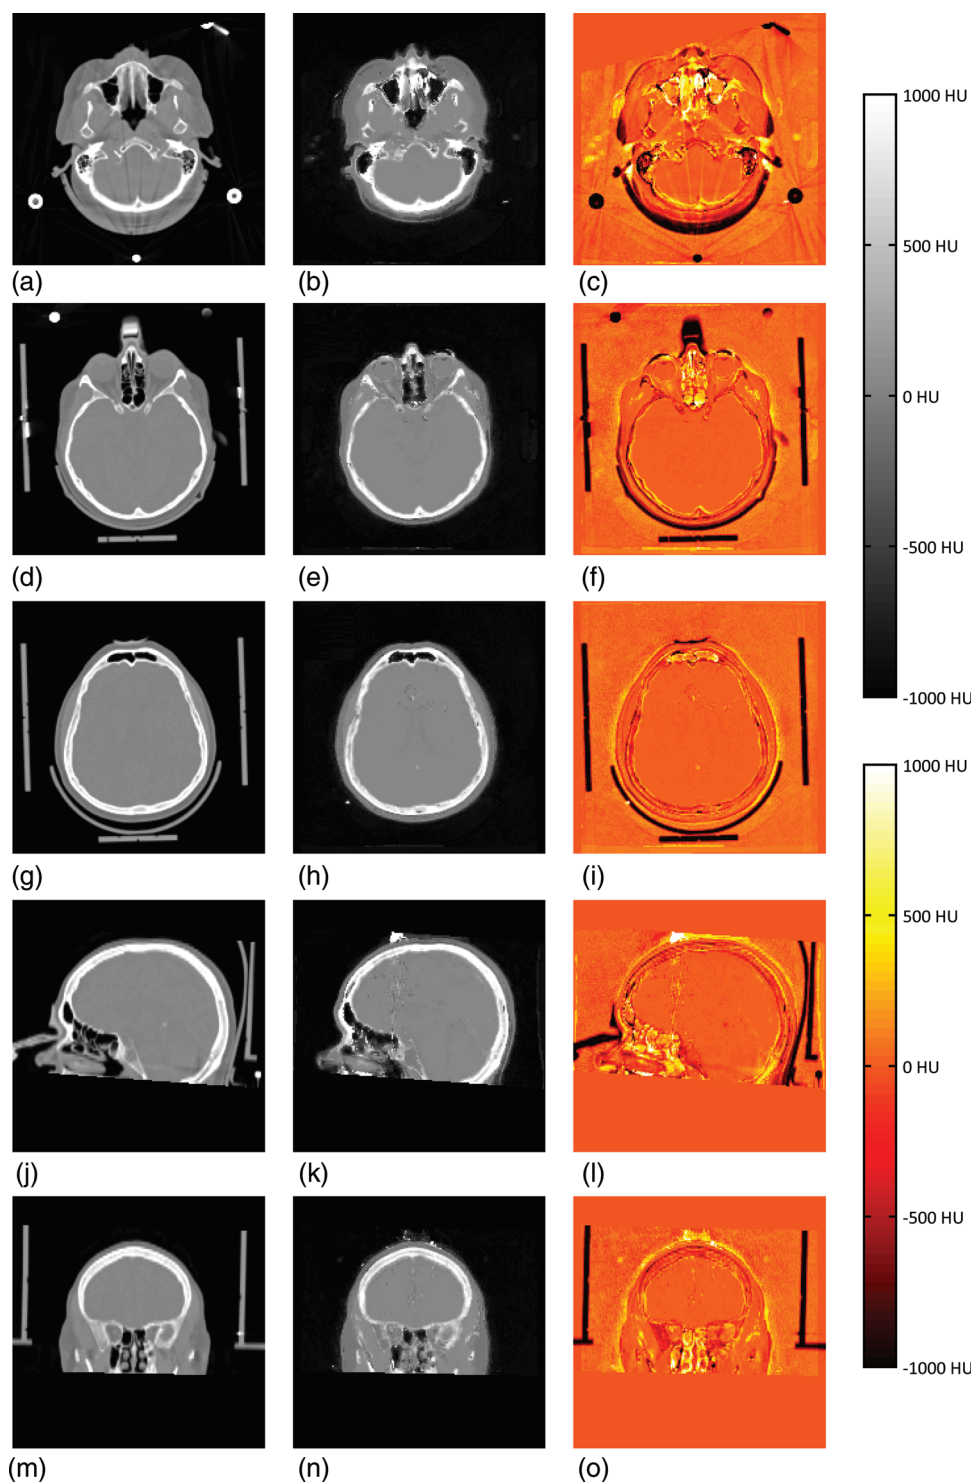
Real CTs [(a), (d), (g), (j), (m)], s-CTs [(b), (e), (h), (k), (n)], and difference images [(c), (f), (i), (l), (o)] of patient 4. The first three rows show transverse slices, the fourth row a sagittal slice, and the fifth row a coronal slice. The upper scale bar belongs to the real and substitute CT whereas the lower belongs to the difference images. For the difference image, a yellow–white tone indicates a higher CT number in the s-CT compared to the real CT and a red–black tone the reversed.
